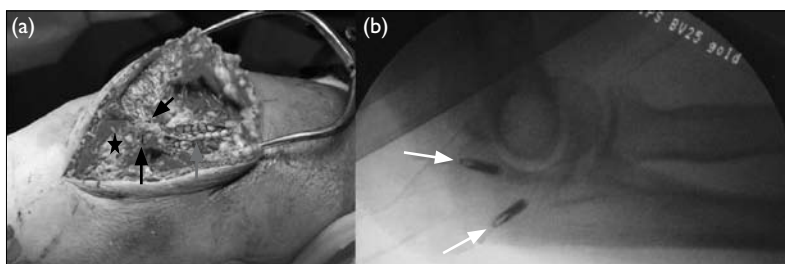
(a) Intra-operative photograph: the triceps tendon (grey arrow) detached from the olecranon distally (black star), was reattached back to the bone using two suture anchors (black arrows) proximally. (b) Intra-operative X-ray screening shows the suture anchors (white arrows) well inserted into the olecranon without breaching the intra-articular surface
